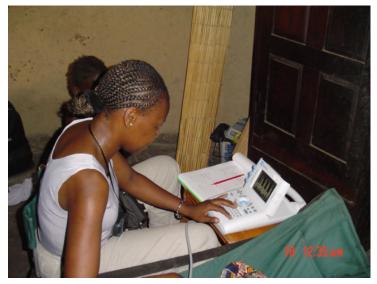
Photograph of a researcher performing echocardiography in an Africa rural setting.
